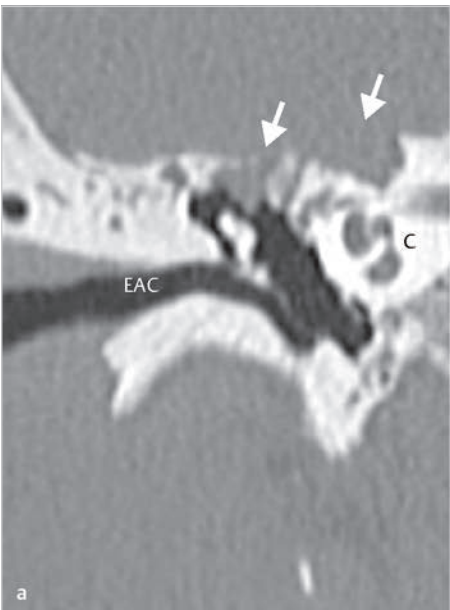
The coronal CT (a) at the level of the head of the malleus shows that the cholesteatoma eroding the middle fossa plate (white arrows) has no relationships with the intact tympanic membrane. The more anterior slice (b) shows severe erosion of the cochlea (yellow arrow) and involvement of the facial nerve located just superiorly to it. C, cochlea; EAC, external auditory canal.
